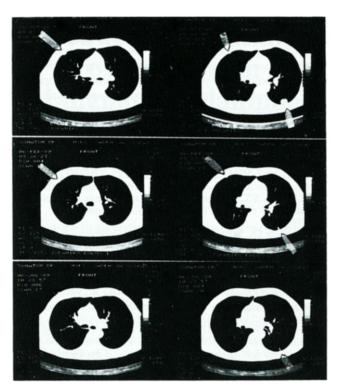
Computed tomography scans showing tumour manifestations before treatment (upper panel), a partial remission after IL-2/dacarbazine treatment (middle panel) and a complete response 3 months after the end of therapy (lower panel).
